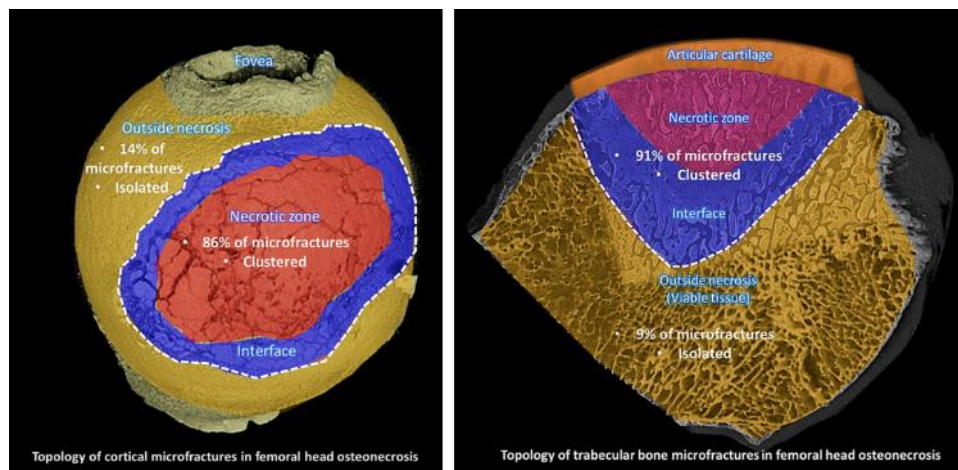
3D μ CT reformats show the distribution of microfractures within the different zones of the necrotic lesion
